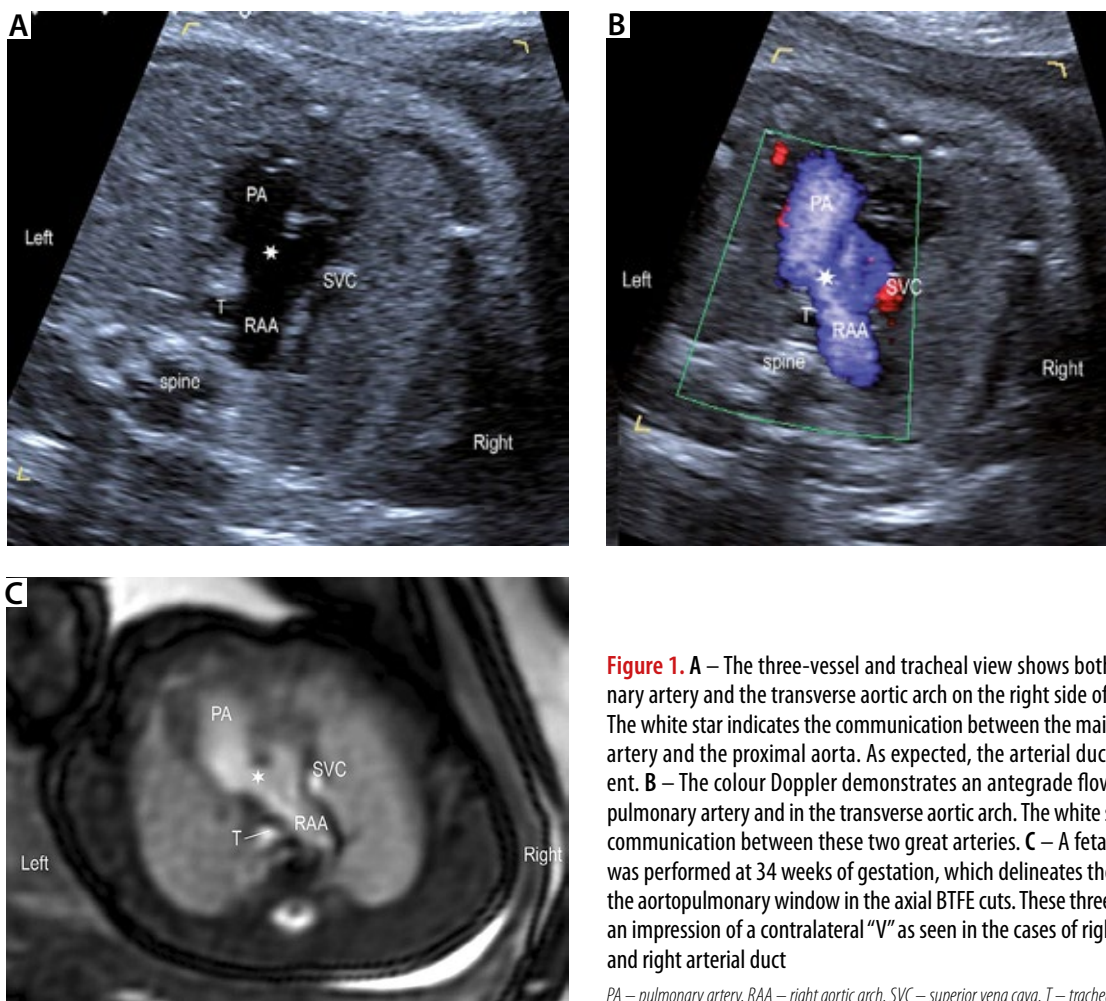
A – The three-vessel and tracheal view shows both the pulmonary artery and the transverse aortic arch on the right side of the trachea. The white star indicates the communication between the main pulmonary artery and the proximal aorta. As expected, the arterial duct is not present. B – The colour Doppler demonstrates an antegrade flow in both the pulmonary artery and in the transverse aortic arch. The white star indicates communication between these two great arteries. C – A fetal cardiac MRI was performed at 34 weeks of gestation, which delineates the anatomy of the aortopulmonary window in the axial BTFE cuts. These three images give an impression of a contralateral “V” as seen in the cases of right aortic arch and right arterial duct
